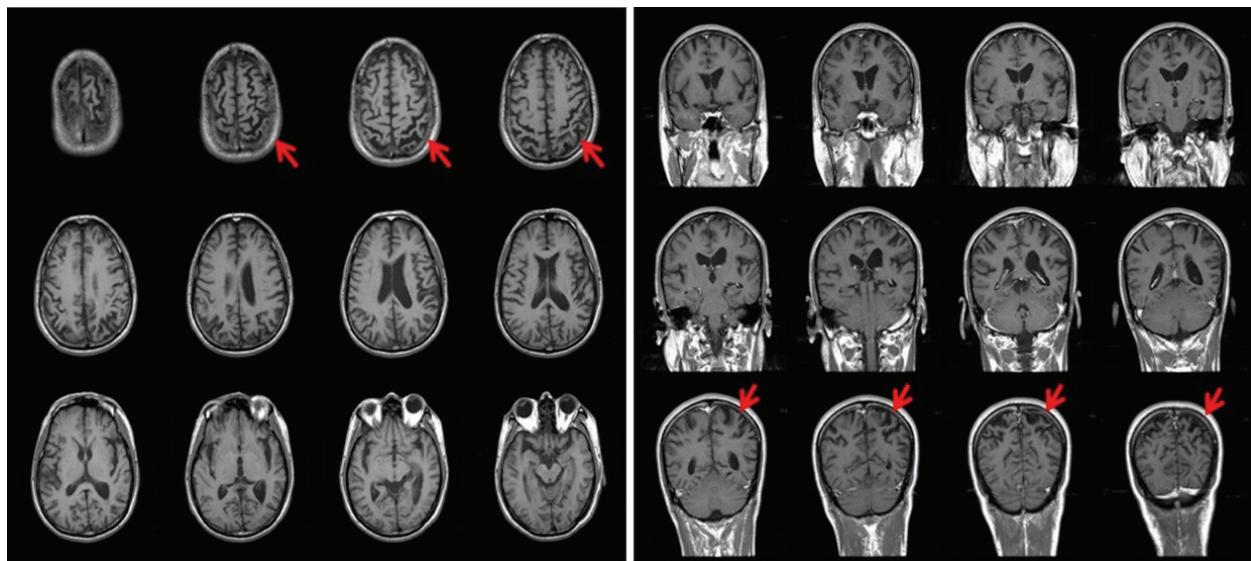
Brain MRI showing significant cortical atrophy in both parietal areas, which was more prominent on the left side with diffuse cortical atrophic changes in T1-weighted images.
